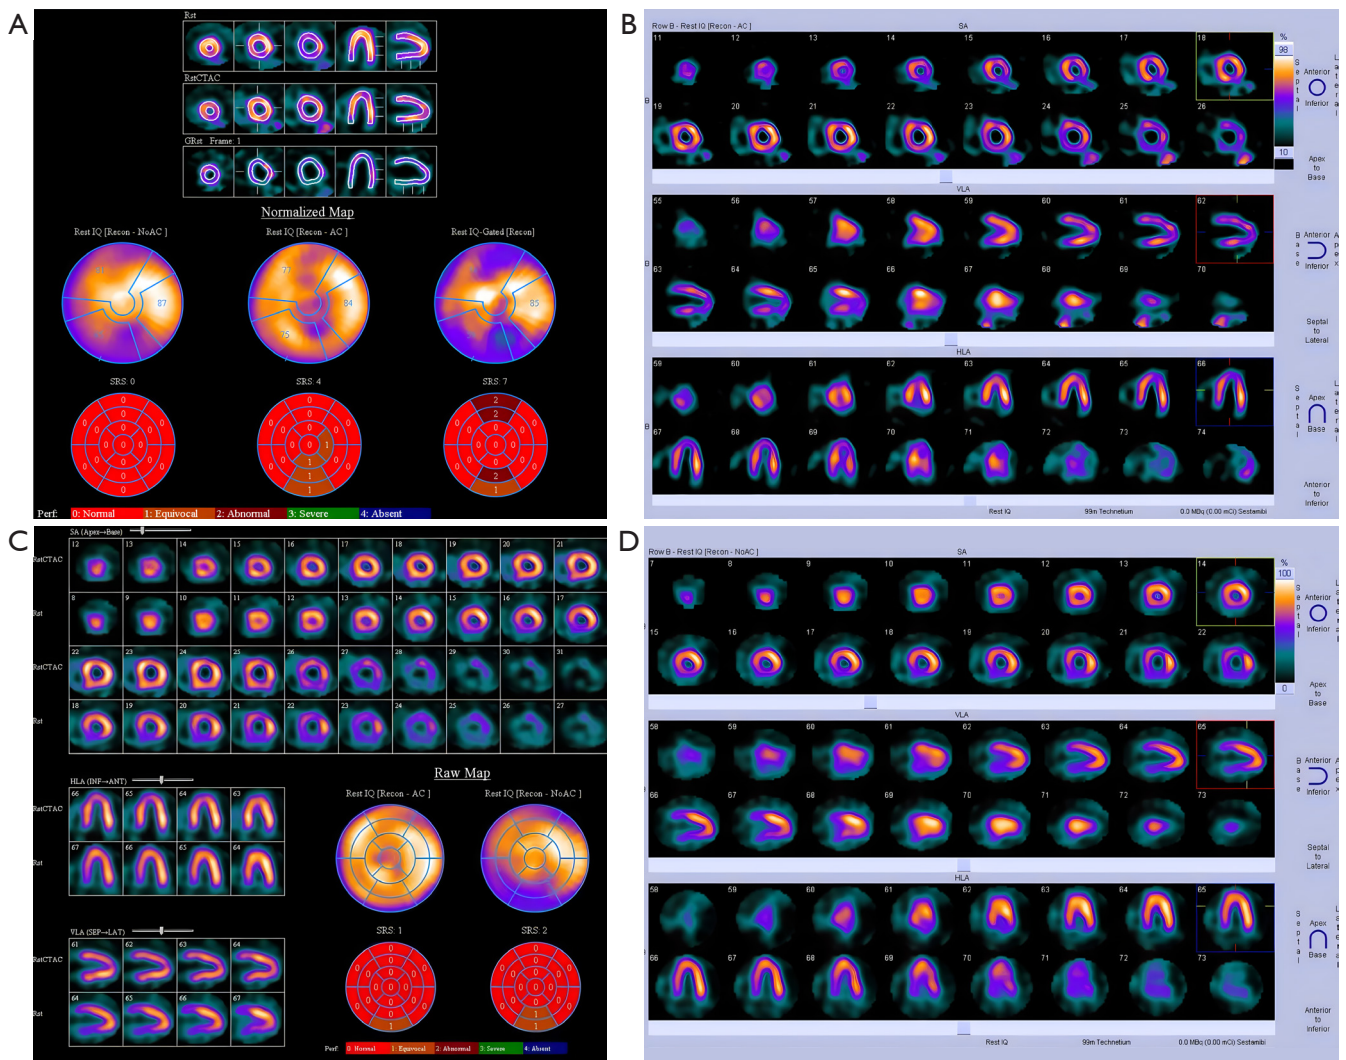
The cardiac ECT. (A,B) Limited radionuclide defects in the apical, anterior, and inferior regions of the left ventricle, indicating the presence of myocarditis. (C,D) A year later, the ECT images revealed a distinct reduction in the size of sparse areas with radioactive distribution in the left ventricle, left ventricular apex, anterior wall, and lower wall compared to previous scans, with some areas showing signs of filling up. Rst, rest; CTAC, computed tomography attenuation correction; GRst, gate rest; IQ, intelligence quotient; Recon, reconstruction; AC, attenuation correction; SRS, summed rest score; Perf, perfusion; SA, short axis; VLA, vertical long axis; HLA, horizontal long axis; INF, inferior; ANT, anterior; SEP, septum; LAT, lateral; ECT, emission computed tomography.
